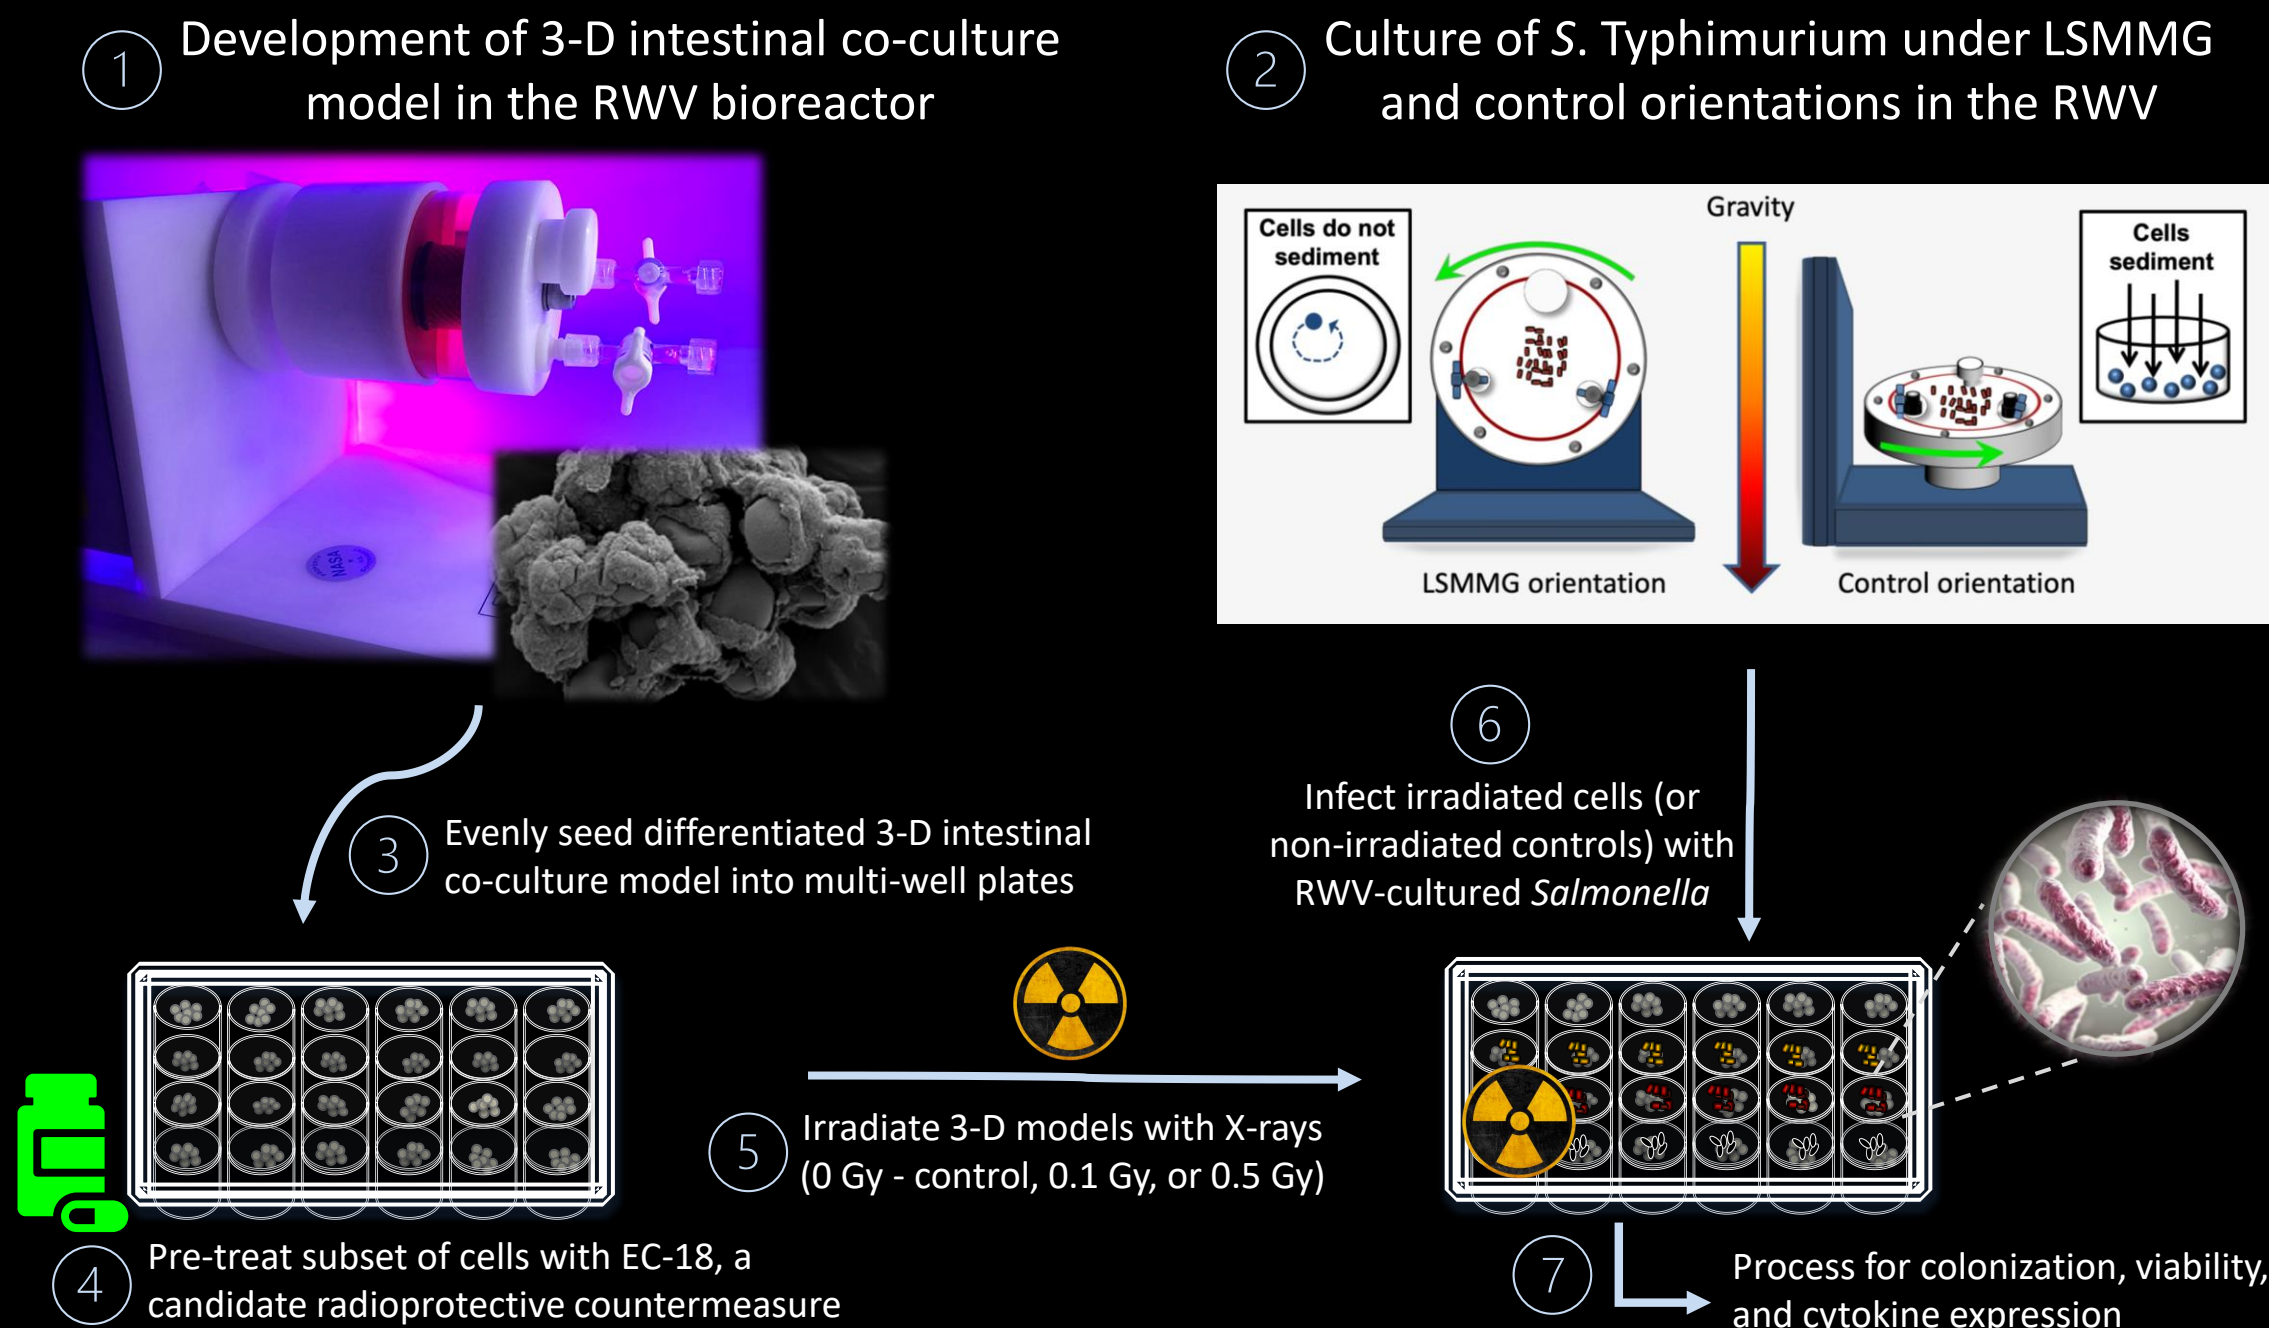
Experimental overview. (1) 3-D co-culture models of human colonic epithelium containing HT-29 epithelial cells and PMA-differentiated U937 macrophages are grown in Slow Turning Lateral Vessel (STLV) bioreactors for 14 days as described (8, 10). (2) *S. Typhimurium* strain χ 3339 is grown in the RWV for 24 hr under LSMMG and control conditions at 37 °C in LB. Non-invasive control strain *E. coli* HB101 is grown shaking for 24 hr. (3) Models are harvested and evenly seeded into multi-well plates. (4) A subset of wells are pre-treated with EC-18, a candidate radioprotective countermeasure. Untreated controls are given 0.05% DMSO (vehicle). (5) 3-D models (treated and untreated) are irradiated with either 0, 0.1 or 0.5 Gy 320 kV X-rays (0.1 Gy/min) on a Precision X-ray, Inc. X-RAD 320 X-ray irradiator. (6) Bacteria are harvested and added to the 3-D co-culture model to a multiplicity of infection of 10. (7) Supernatants are collected and processed for lactate dehydrogenase assays (LDH/viability) and cytokine analyses. For colonization studies: at 30 minutes post-infection (adherence), samples are rinsed with Hank's Balanced Salt Solution (HBSS) in triplicate. A subset of the wells receive 0.1% sodium deoxycholate to lyse host cells and remaining wells receive media containing 50 μ g/mL gentamicin. Lysed samples are serially diluted and plated. At 3 hours post-infection (h.p.i.), a subset of the samples are washed with HBSS, lysed in 0.1% sodium deoxycholate, serially diluted and plated to evaluate the percentage of bacteria that have invaded into the cells. Remaining cells receive media containing gentamicin at 10 μ g/mL. Washes, serial dilution and plating steps are repeated at 24 h.p.i. for remaining wells for intracellular survival.
